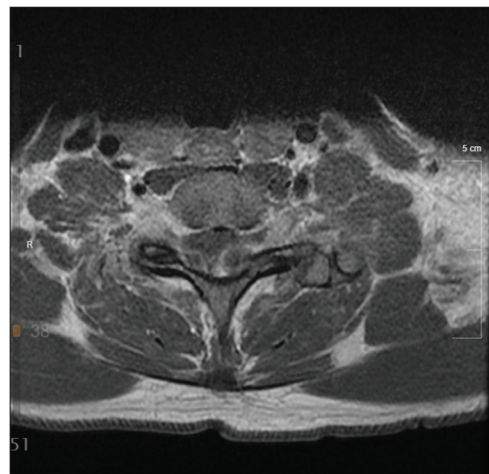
Transverse view of magnetic resonance imaging of spine at cervicothoracic junction showing bilateral synovial cysts.
